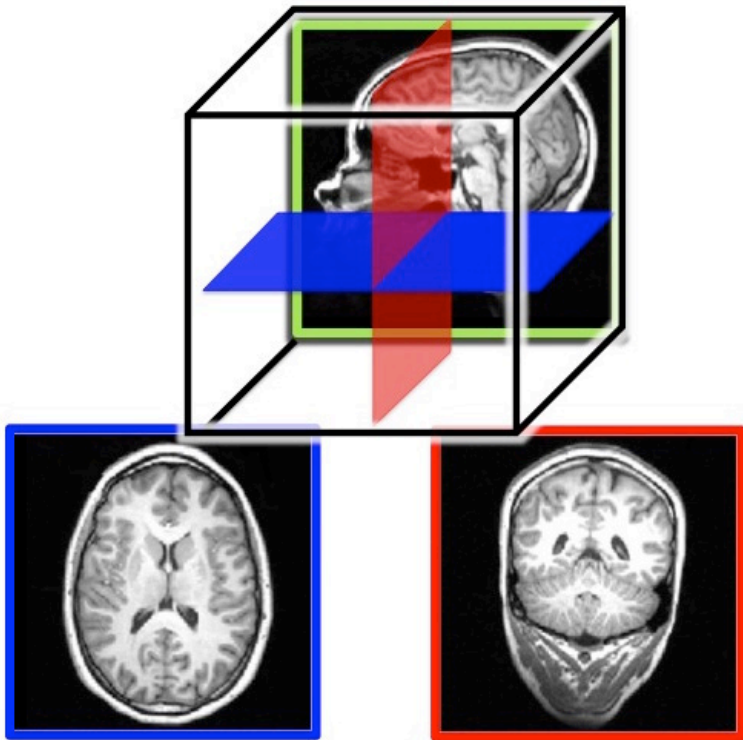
MRI slices of the human brain. Both the outer gray matter and inner white matter are visible in each image. The brain is a three-dimensional (3-D) structure, but an image is two-dimensional (2-D). Here, we show example slices of the three possible 2-D cuts through the brain: a sagittal slice (top image), a horizontal slice (bottom left), which is also known as a transverse or axial slice, and a coronal slice (bottom right). The bottom two
